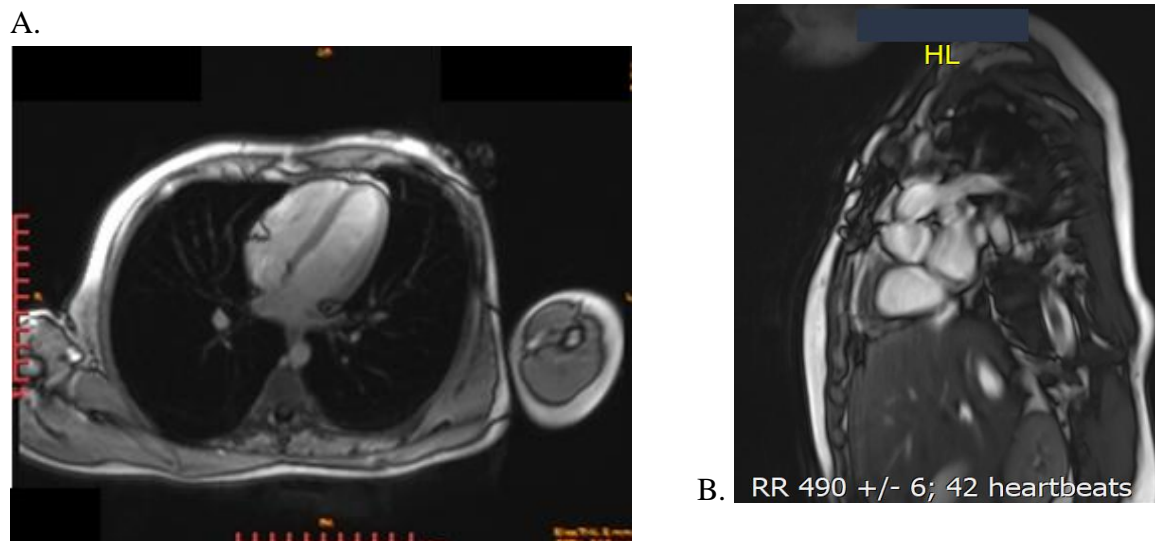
Cardiac computed tomography in SARS-CoV-2 infection in pediatric patients with MIS-C. A four-camera image of a ten-year-old female patient with a healthy heart.
